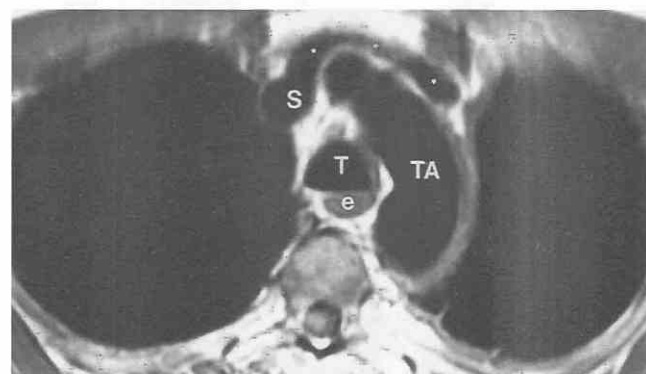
Axial MR image of the aortic arch in a patient with mesothelioma of the left hemithorax. e, esophagus; S, superior vena cava; T, trachea; TA, transverse aortic arch. The asterisks indicate the left brachiocephalic vein.
